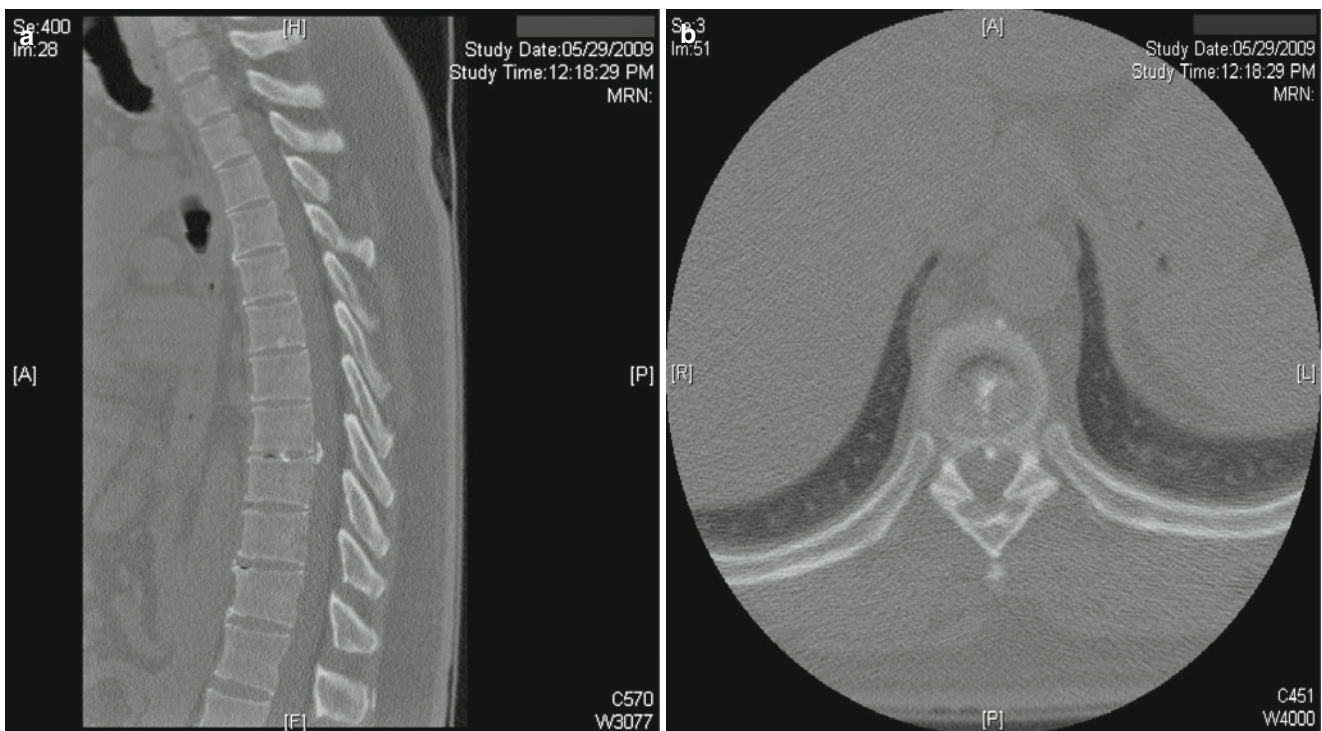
Thoracic herniated disc on CT. (a) A T8–9 herniated disc on sagittal CT. (b) Axial CT showing calcification in the T8–9 disc herniation
